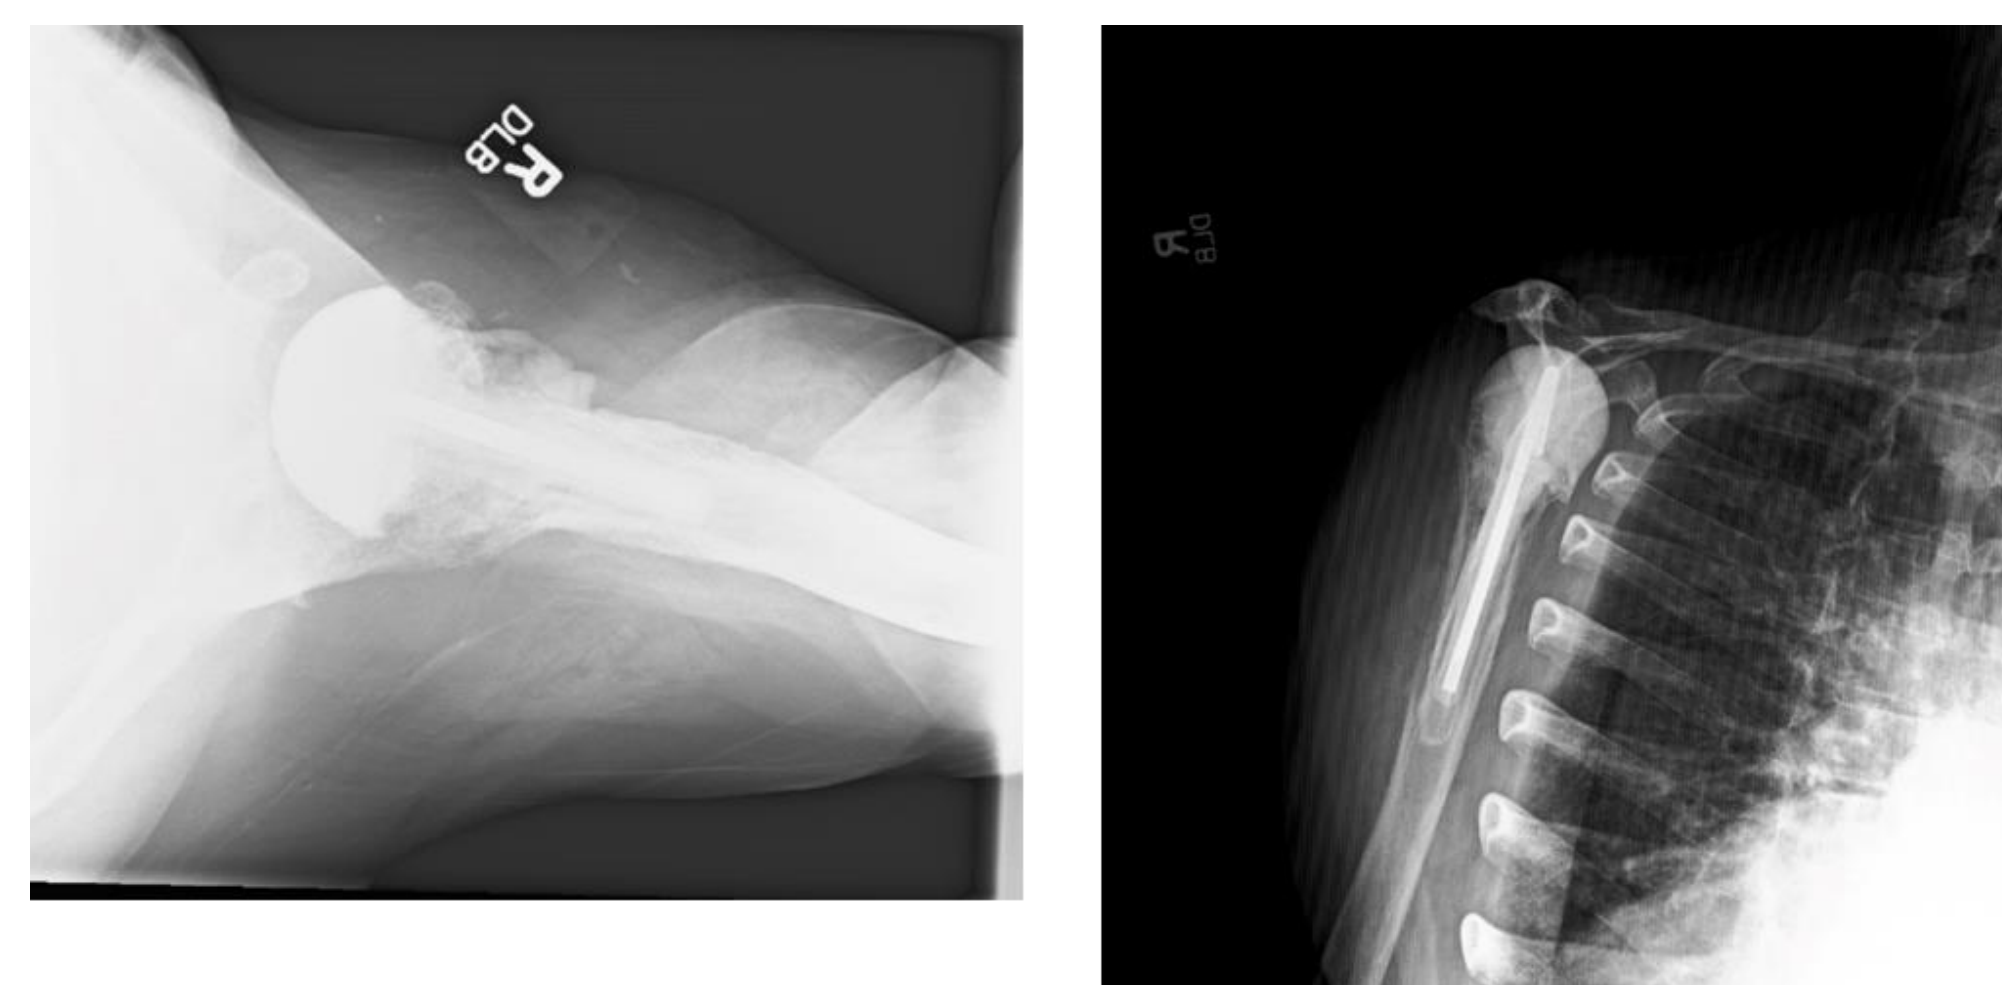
Radiographs revealing explanation of the anatomic shoulder arthroplasty and insertion of the antibiotic spacer. Placed for six months.
